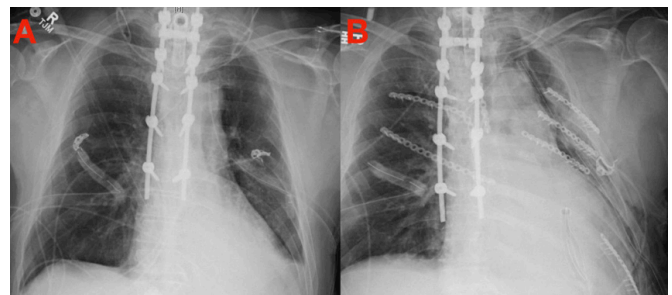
Figure 2A depicts an anterior-posterior preoperative chest x-ray and Figure 2B depicts an anterior-posterior postoperative chest x-ray following rib fixation.
